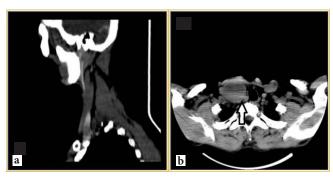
CT -SCAN showing (a and b) a well-defined cystic mass in the right lower carotid space. (a) Sagittal section and (b) Contrast axial sections.
